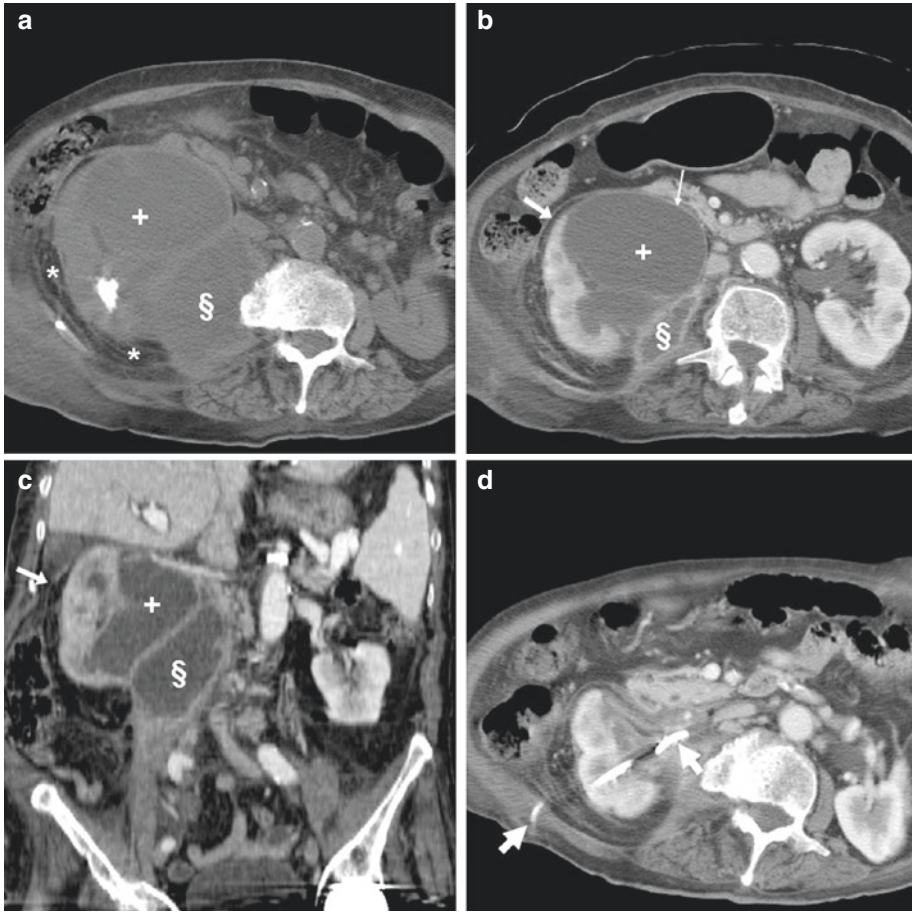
An elderly female with septic fever and abdominal pain had CT diagnosis of severe right-sided hydronephrosis (+) with associated perinephric fat stranding (on unenhanced image a), hyperenhancing pyelic wall (thin arrow), fascial effusion (arrows) and psoas muscle abscess
